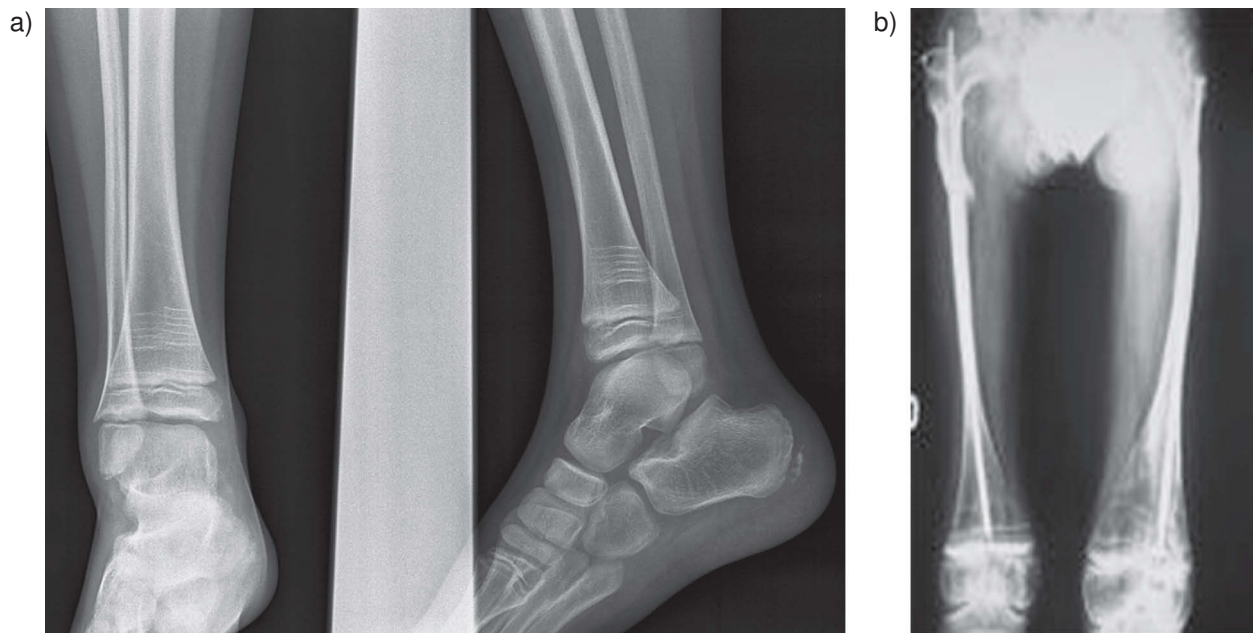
X-ray images of 2 children with OI Treated with bisphosphonates. Zebra lines may be seen in the metaphyseal region of the long bones. a), boy with moderate involvement, and b), boy with severe involvement.
